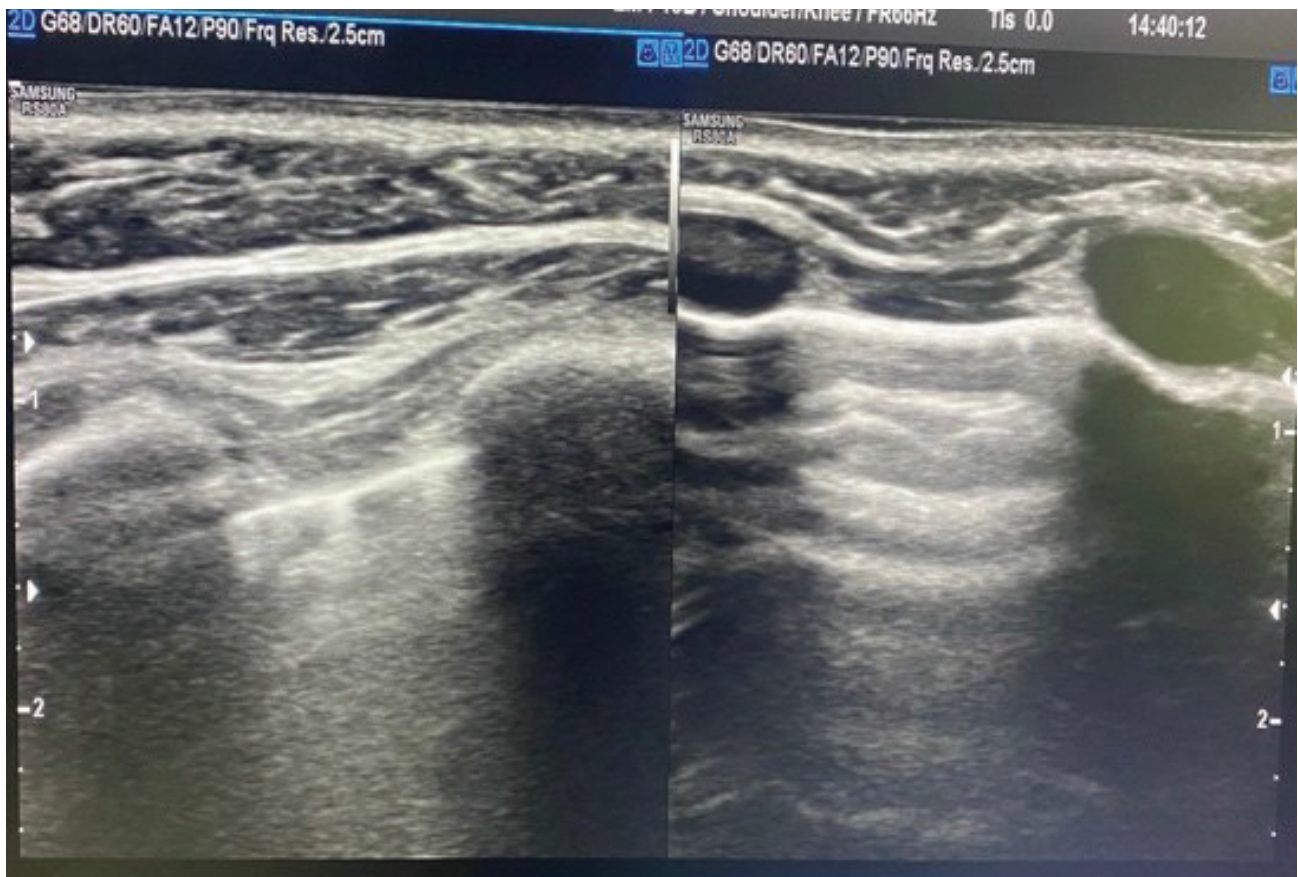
Ultrasound examination confirmed this muscle absence
